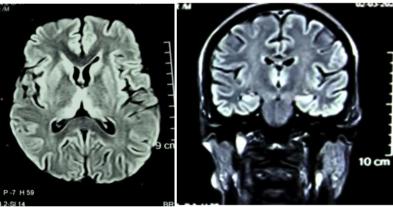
MRI brain of a patient with wernickes encephalopathy showing Flair hyperintesities in medial thalami and peri aqueductal area.
